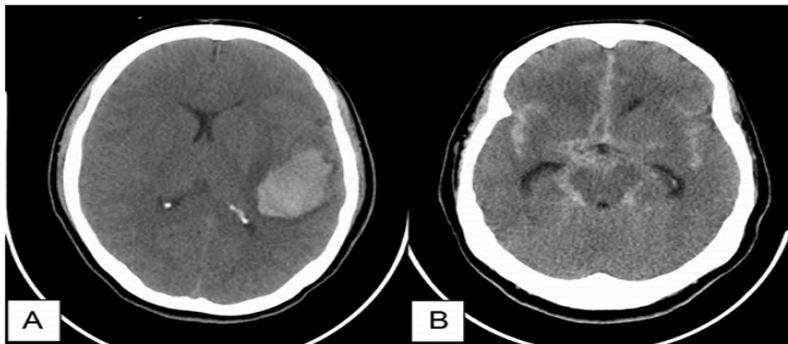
A) CT scan revealed left temporal lobe intracerebral hemorrhage, B) An extensive of subarachnoid hemorrhage. This is seen as hyperdensity involving the basal cisterns with extension into the ventricular system.
